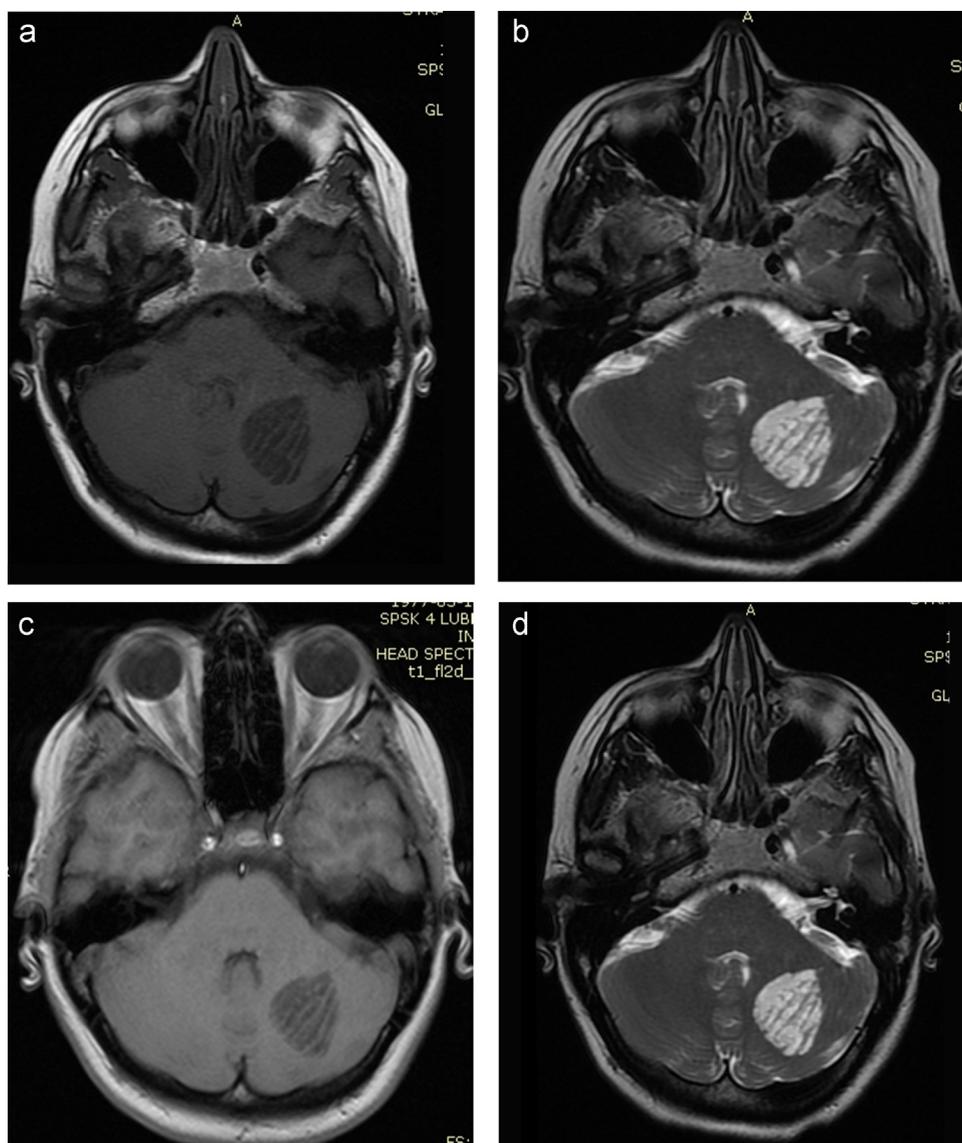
Magnetic resonance imaging of the brain performed in November 2011 (A and B) and in February 2013 (C and D) – Progression has not been observed. (A and C) T1-weighted axial images showing hypointense tumor of left cerebellar hemisphere with isointense strips. (B and D) T2-weighted axial images showing hyperintense lesion with linear hypointensity strips. Cerebellar alteration slightly compresses fourth ventricle. The “tiger-striped” MRI appearance of this lesion is characteristic of Lhermitte-Duclos disease.
